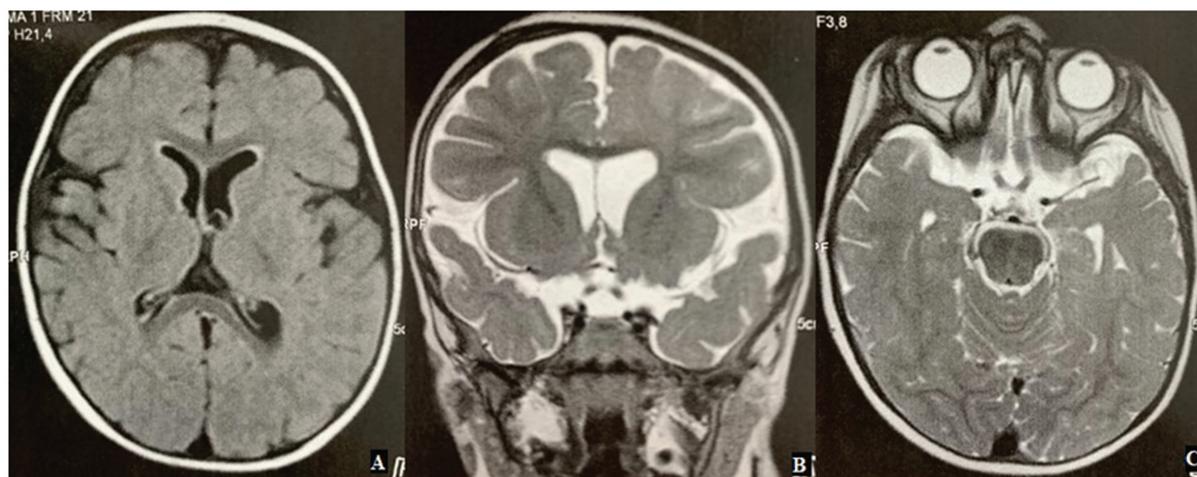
Control skull MRI one year after the procedure, showing complete resolution of the pathology. (A) Fluid attenuated inversion recovery-weighted skull MRI in axial section. (B) Coronal T2-weighted MRI of the skull. (C) Axial T2-weighted MRI of the skull.
